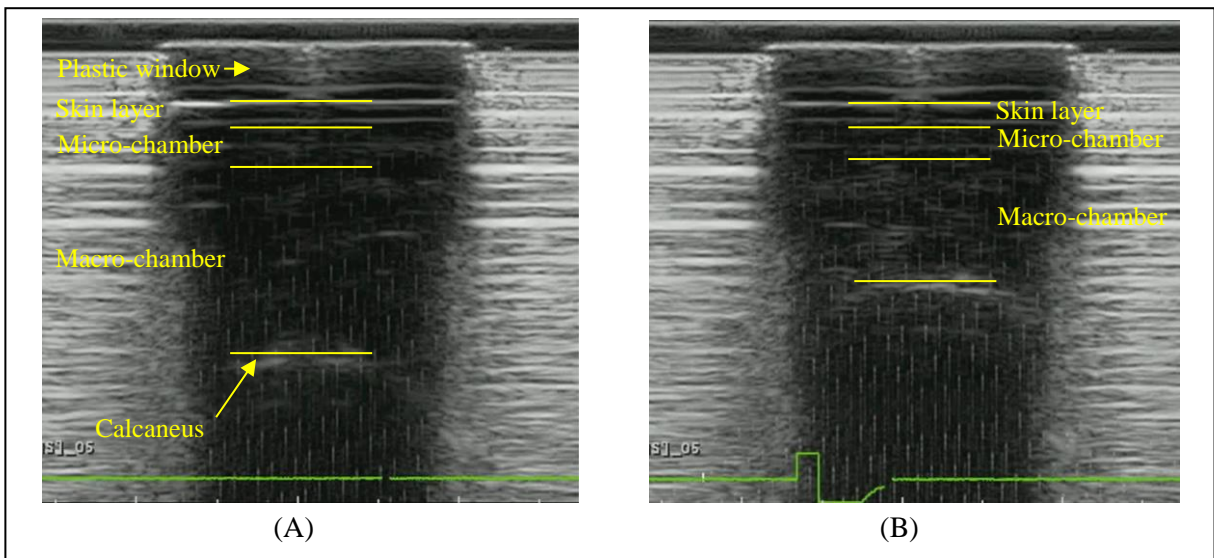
Ultrasound images for the frontal view at the location of calcaneus tuberosity: (A) Unloaded heel pad; (B) Loaded heel pad.
